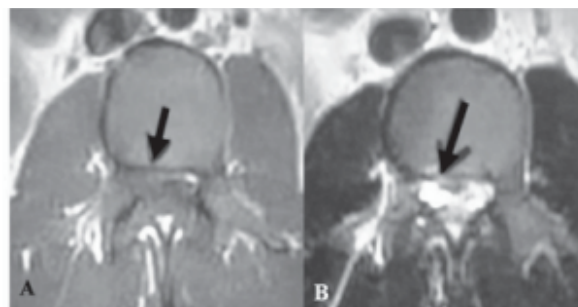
MRI axial sections of lumbar spine at L2-3 level, A) T1W image, B) T2W image showing the lesion
